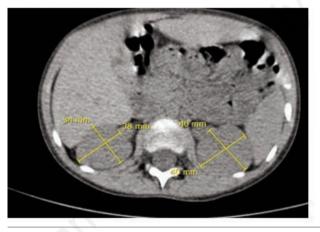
Computed tomography of the abdomen. Panel A: right and left kidney longitudinal diameters - Panel B: transversal diameters.
